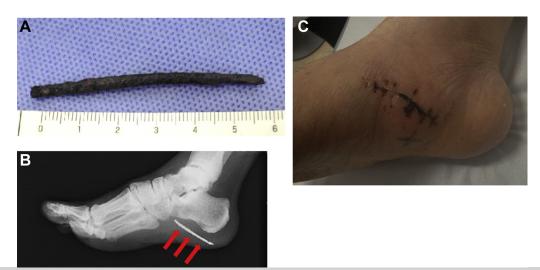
Photographs and radiograph of the trauma. A, Photograph of the rusty nail. B, Radiograph of the right foot in lateral view. *Red arrows*, shadow of the rusty metal nail. C, Photograph of the right foot on day 30 after the injury.
